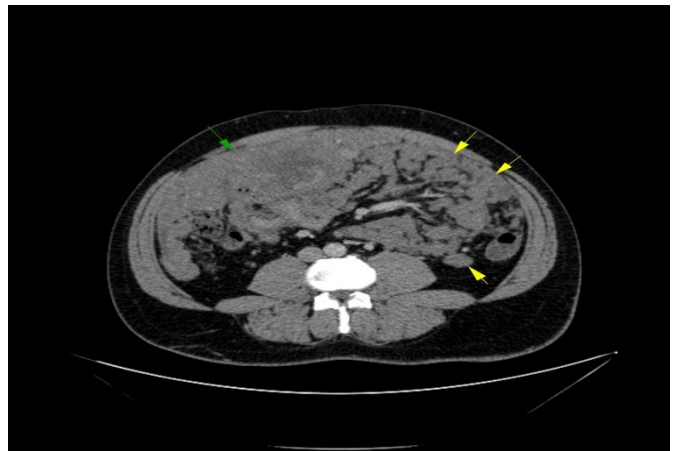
CT abdomen with IV contrast, shows large mass in right side of abdomen in between abdominal wall and bowel loops "green arrow", multiple conglomerate peritoneal nodules "yellow arrows"
